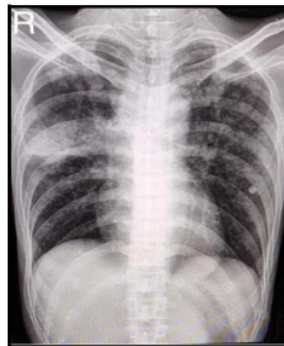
Plain chest radiograph. This indicates the presence of bilateral pneumonia which is thought to occur in a specific process (tuberculosis infection) and aortic extension.
